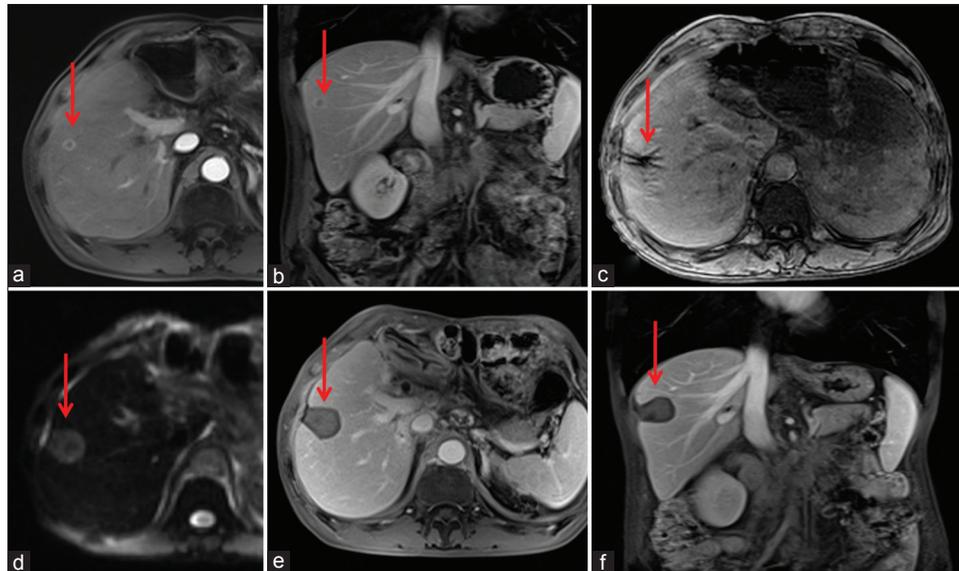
Magnetic resonance imaging-guided radiofrequency ablation for liver cancer in a 62-year-old man. (a) Axial and (b) coronal show a small tumor located in segment V, which exhibits fast wash-in in arterial phase and fast wash-out in portal venous phase; (c) The insertion of electrode, and the multiple subneedle tips unfold and cover the tumor ideally; (d) axial, (e) axial, and (f) coronal show the ablation zone with an enough ablation margin exhibiting high signal on diffusion-weighted imaging and no enhancement on contrast-enhanced magnetic resonance imaging 10 months later
